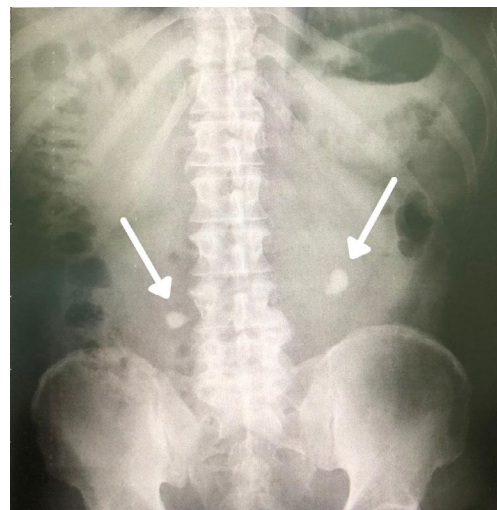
Abdominal x-ray showing bilateral kidney stones.
